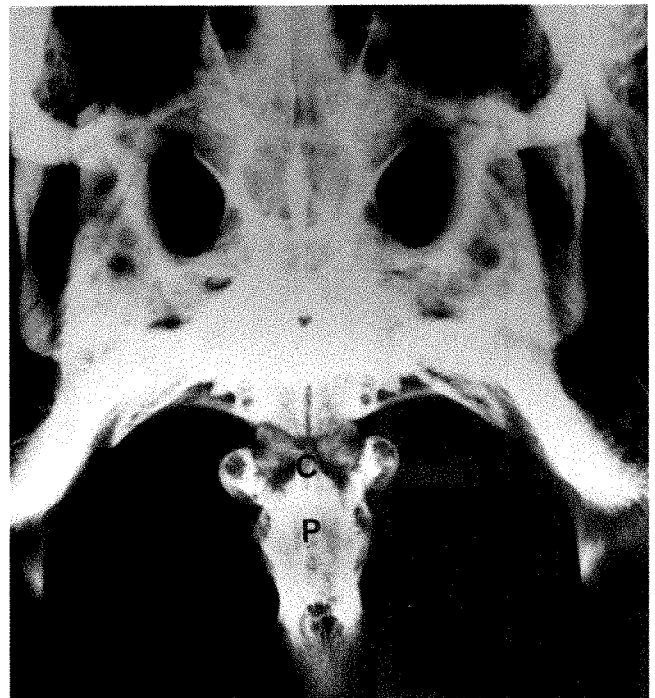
Radiograph of craniovertebral border of alligator skull demonstrating proatlas (P) articulating with single occipital condyle (C).
